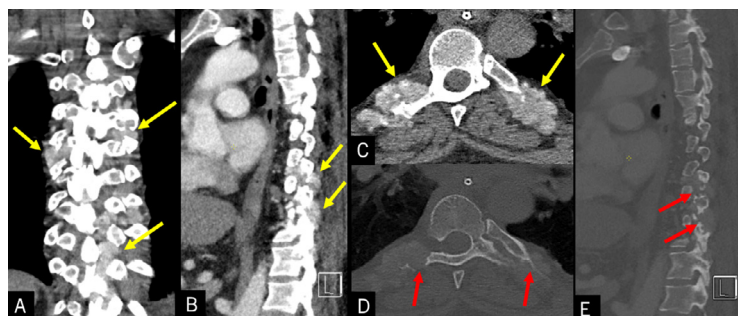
(A–C) Coronal, sagittal, and axial CT reformat demonstrate multiple paraspinal soft tissue masses with internal amorphous calcification (yellow arrows). (D–E) Axial and sagittal CT reformat with bone kernels demonstrate sharply demarcated osseous erosions (red arrows).
